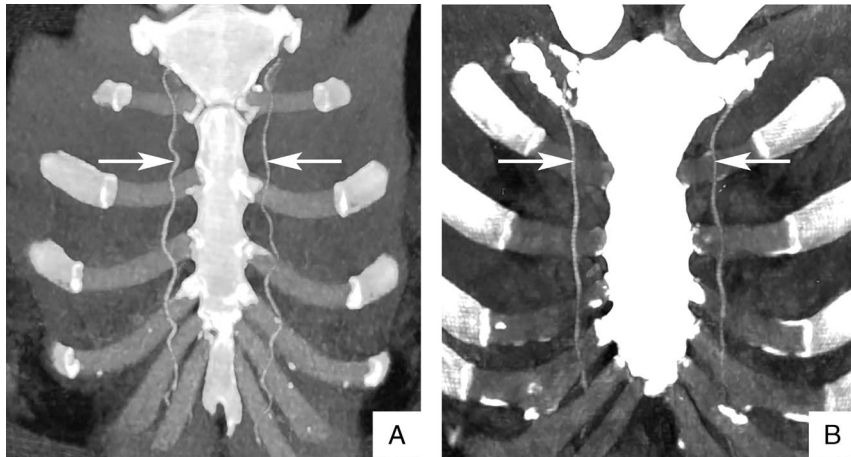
Reformatted maximum-intensity projection images of a 52-year-old woman and a 47-year-old woman with right breast cancer obtained by CTA₃₇₀ (A) and 40 keV MEI (+)₃₀₀ (B), respectively. The quality of the CTA₃₇₀ image is slightly better than that of the 40 keV MEI (+)₃₀₀. The visualization of the internal thoracic artery was comparable between CTA₃₇₀ and 40 keV MEI (+)₃₀₀. The arrow points to the internal thoracic artery.
